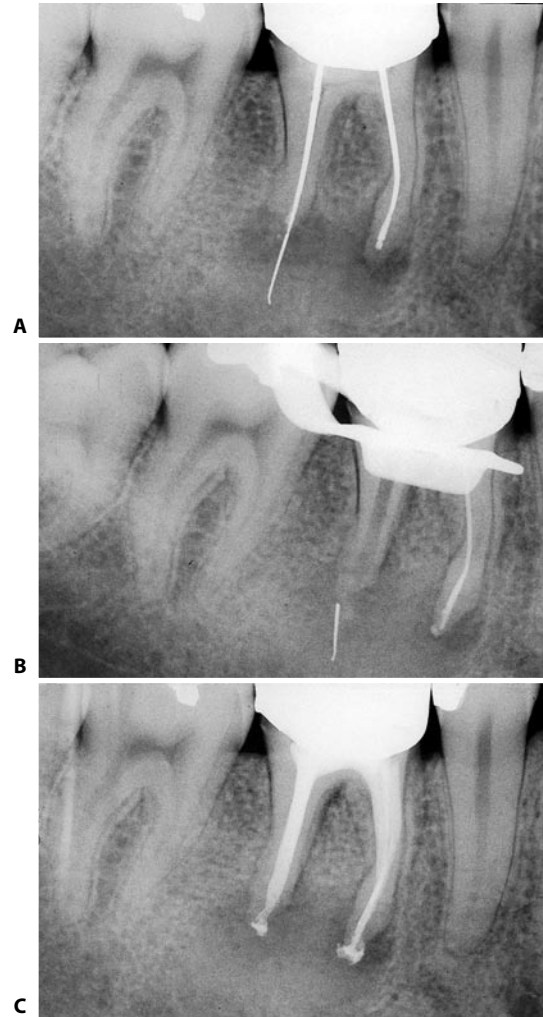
The silver cone is seen emerging beyond the apex by several millimeters. It has become corroded, causing the separation of the cone into two fragments at the level of the apical foramen. A. Preoperative radiograph. B. The silver cone has been removed from the distal canal, but the part beyond the apex has remained in the tissues. The patient then developed an acute alveolar abscess. The tooth remained completely open for drainage for several days, and the patient was invited to rinse with warm salt water to encourage drainage. C. Postoperative radiograph obtained after one week. The silver cone fragment has been “drained” externally, together with the purulent exudate.
